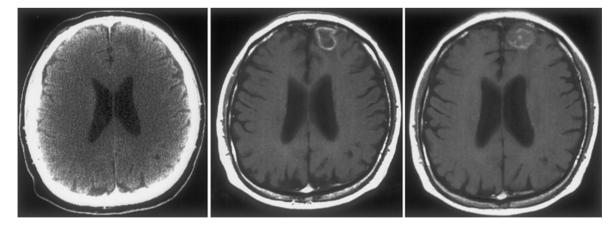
Metastatic renal cell carcinoma. Axial contrast enhanced CT scan from day of radiosurgery (left), and axial, T1 weighted, gadolinium enhanced MRI from 8 months (center) and 11 months (right) after radiosurgery. The patient received 21 Gy to the 83% isodose surface of a 1.0 cc tumor. The radiographic abnormality has increased in size, but shows ring enhancement only.
